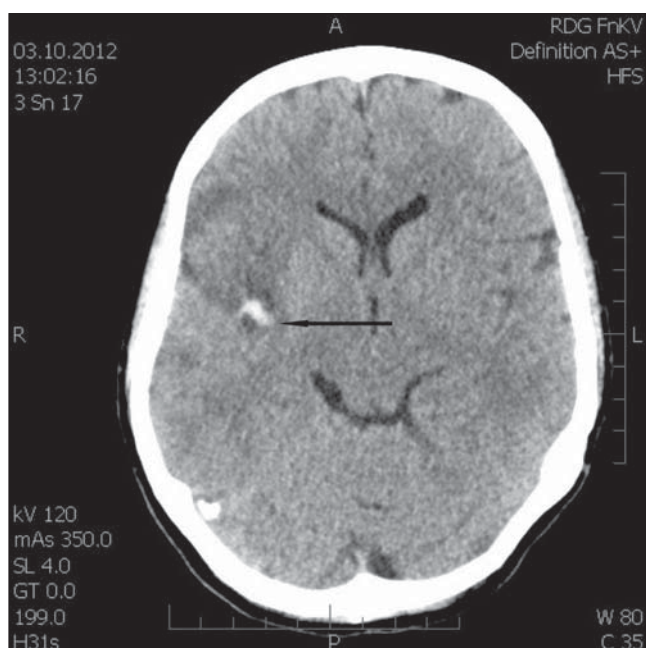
CT scan after 24 hours. Residual ischemic hypodense lesion with small hyperdensity at the right fronto-temporal part (see arrow).
